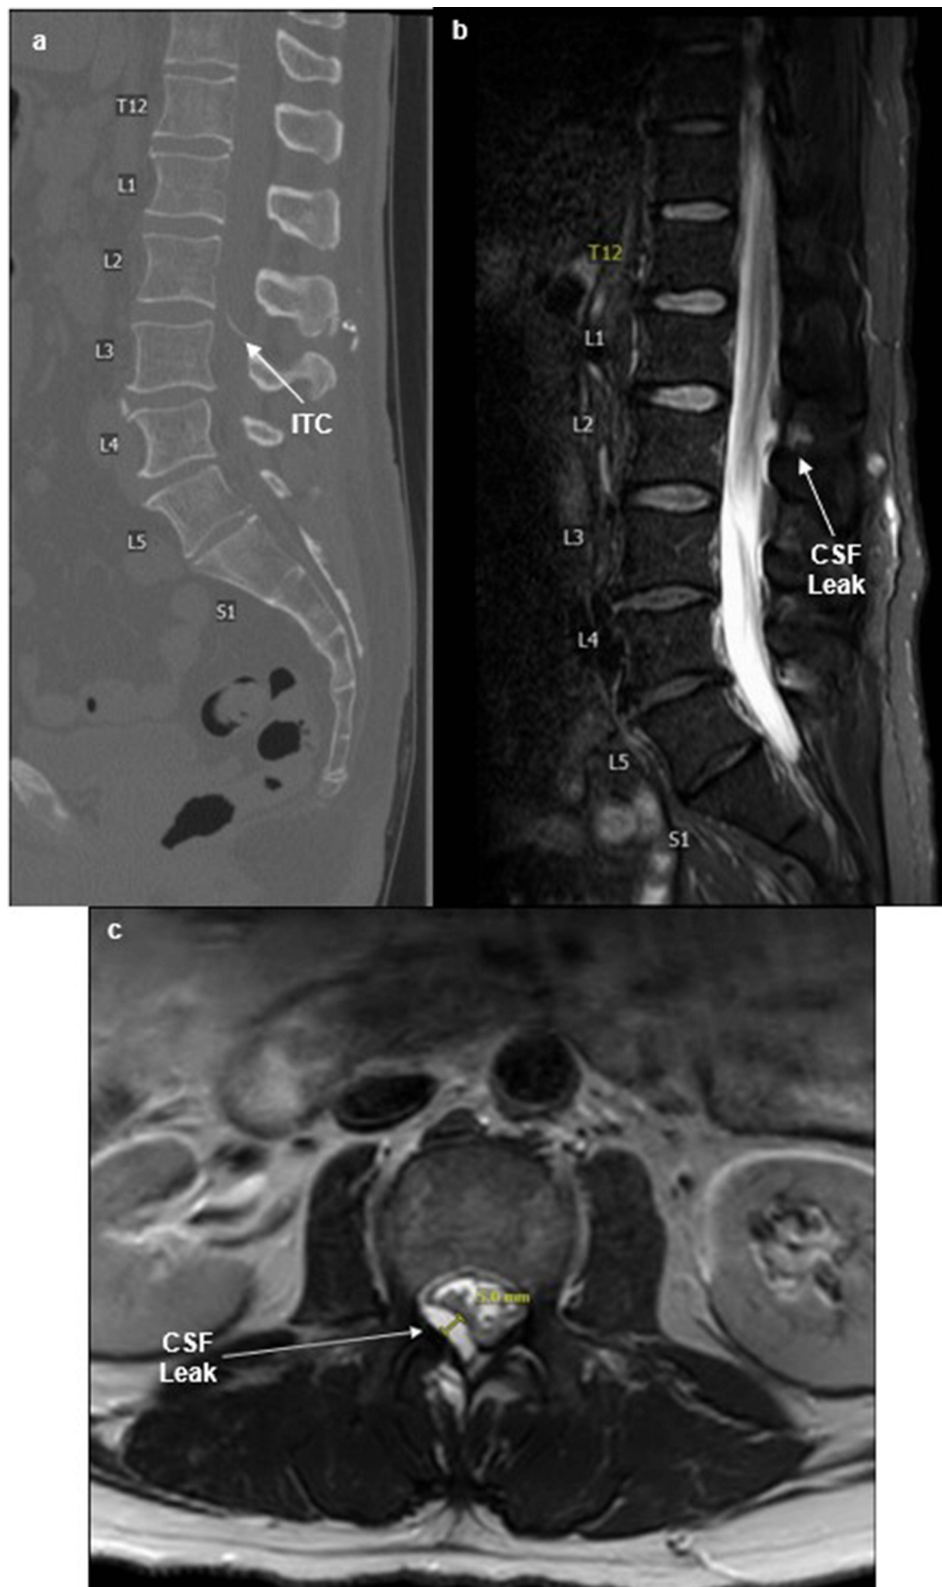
Midline sagittal CT of lumbar spine showing the entry at L2–L3 and the projection of ITC toward the anterior portion of the intrathecal space indicated by arrow in panel (a), midline sagittal MRI of lumbar spine identifying CSF collection in the posterior epidural space at L1–L2 level indicated by arrow in panel (b), and axial view of MRI at L1–L2 level demonstrating a 5 mm fluid pocket suspicious for CSF leak on the right side of the posterior epidural space indicated by arrow in panel (c).
